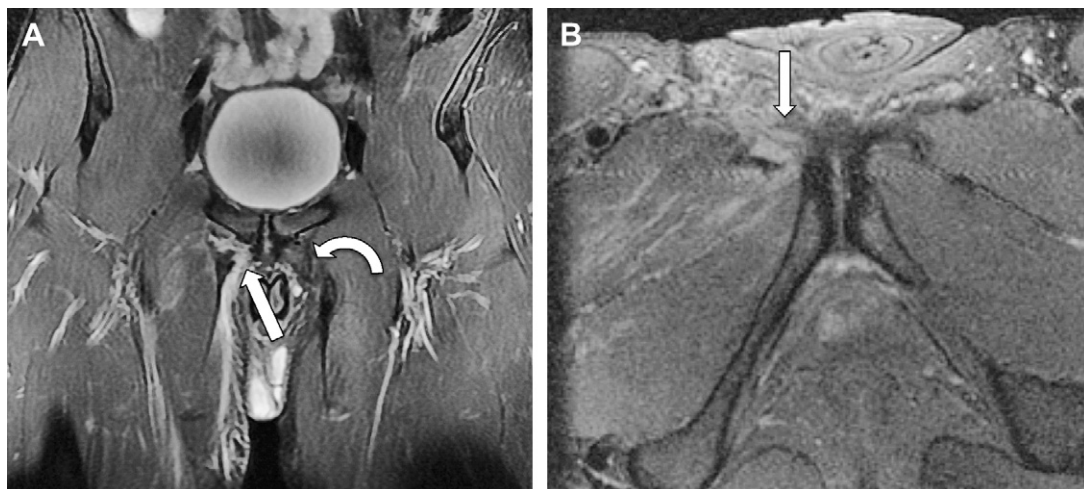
(A) Coronal fat-saturated T2-weighted MR image. Hyperintense signal abnormality at the origin of the right adductor longus tendon (*straight arrow*) consistent with an acute tear. Chronic tear of left adductor longus as evidenced by thickening and hypointensity with retraction of the tendon and healing with scar formation (*curved arrow*). (B) Axial fat-saturated T2-weighted MR image demonstrating acute right adductor longus tear (*arrow*).
